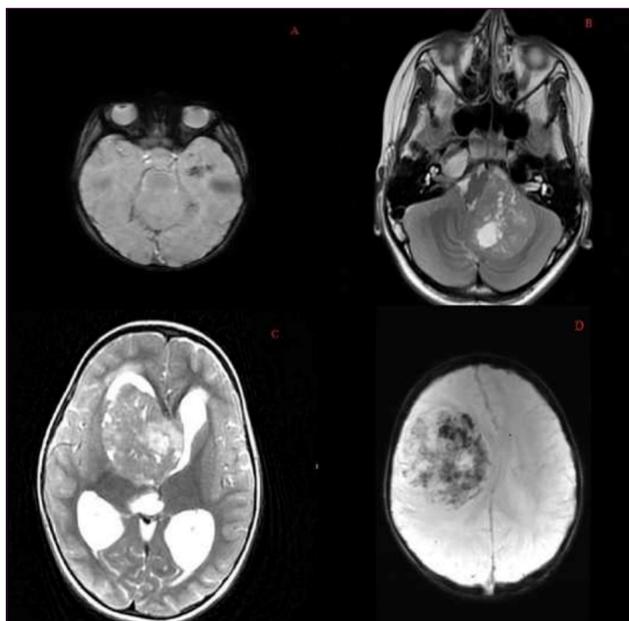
A: Magnetic resonance imaging (MRI) of the brain revealed a calcific and partially cystic heterogeneous mass in the left temporal area (2x3 cm) B: Magnetic resonance imaging of the brain revealed a mass (3.5 x 2.5cm) in the posterior fossa C: Magnetic resonance imaging of the brain revealed a mass in the right lateral ventricle (5x6x6.4) D: Cranial MRI showed a mass in the frontal region (7.5x6.2x6.1 cm)
